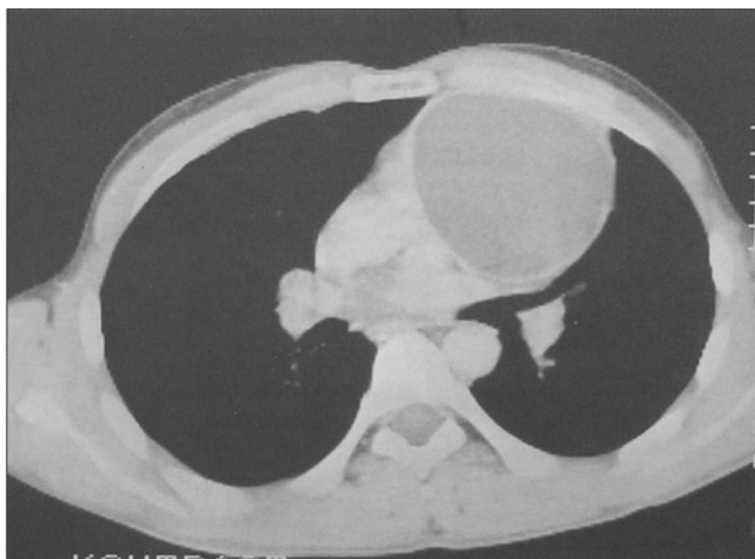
CT scan of a mediastinal hydatid cyst.
